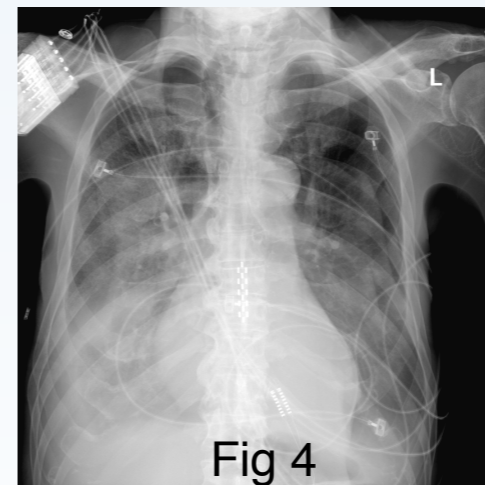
Pre-thoracocentesis X-ray showed bilateral pleural effusions with bibasilar infiltrates.
